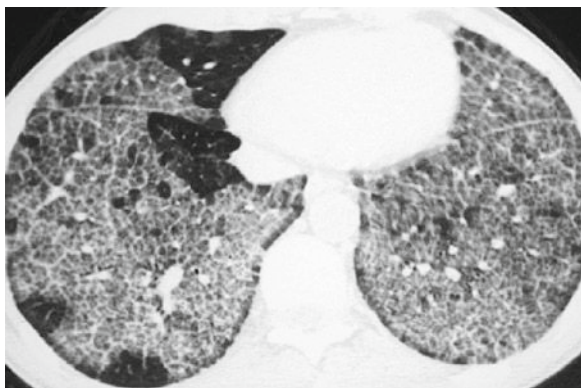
High-resolution computed tomography scan in 65-year-old man hospitalized for acute respiratory distress. It was related to secondary PAP related to silica exposure. This image demonstrates “crazy paving,” which refers to bilateral ground-glass opacity that is associated with marked interlobular septal thickening and a sharp nonanatomic demarcation between normal and abnormal lung
